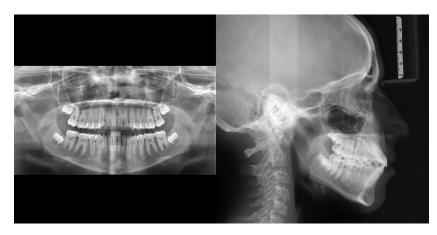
Posttreatment radiographs showing acceptable root parallelism, no root resorption and improved skeletal Class relationship.
